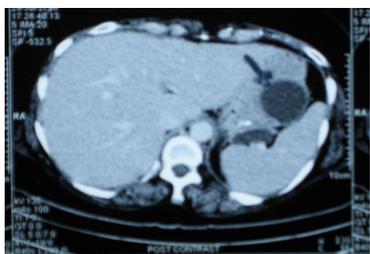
CT SCAN OF ABDOMEN - Pseudocyst of pancreas with necrosis in tail of pancreas
